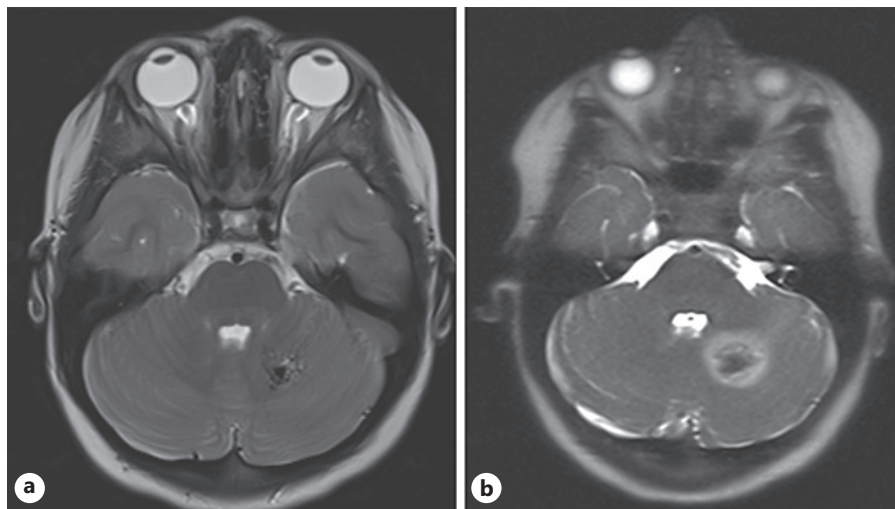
a Pre-procedure axial MRI showing no edema. b Post-embolization axial MRI demonstrating new perinidal edema.
